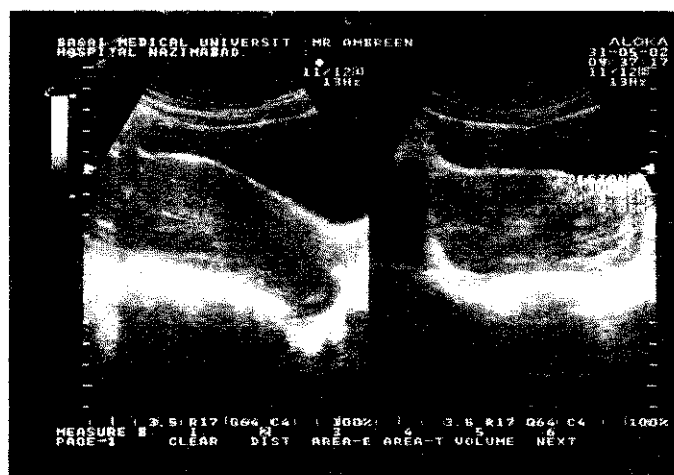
a: Ultrasound showing fluid in pelvis.
